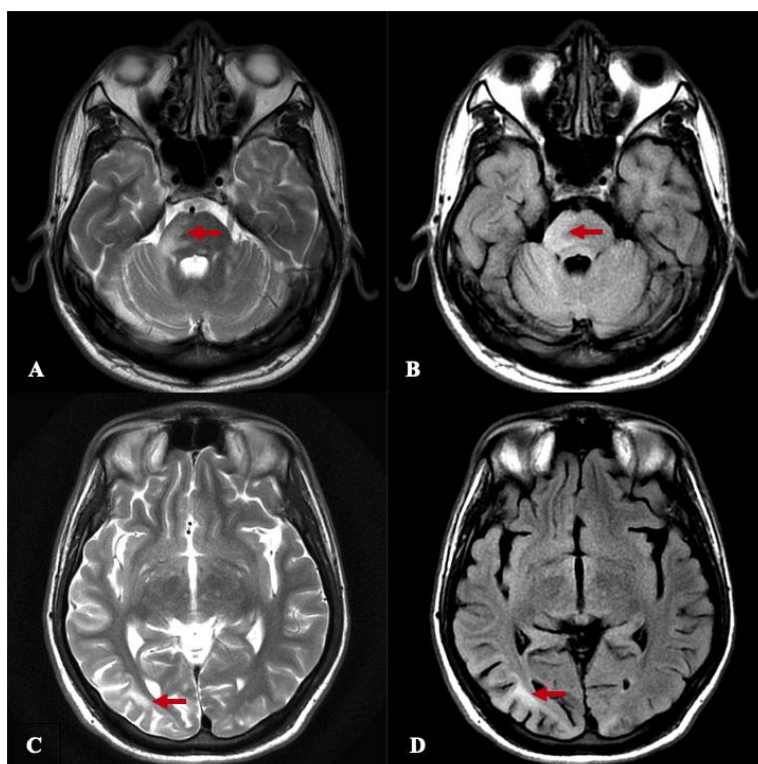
Brain MRI of a people living with HIV with a cerebral toxoplasmosis infection showing hyperintensity on T2 (A,C) and FLAIR (B,D) in the pons and subcortical of right temporo-occipital (red arrow) suggesting as an ADEM case.
